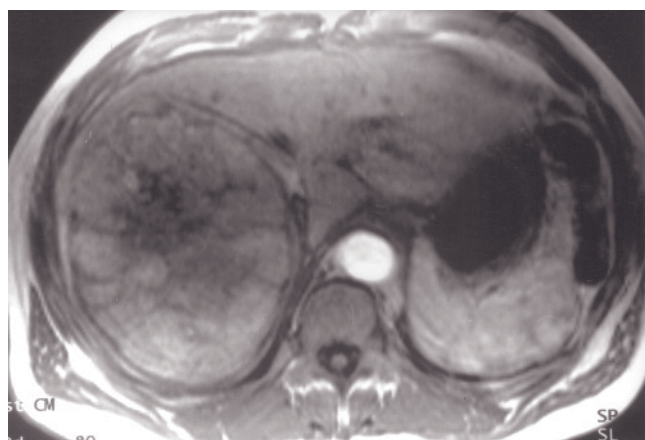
(*Continued*) that the HCCs are more evident on early-phase postgadolinium MR images (arrow, *e*, *g*) than on the multidetector CT images.
